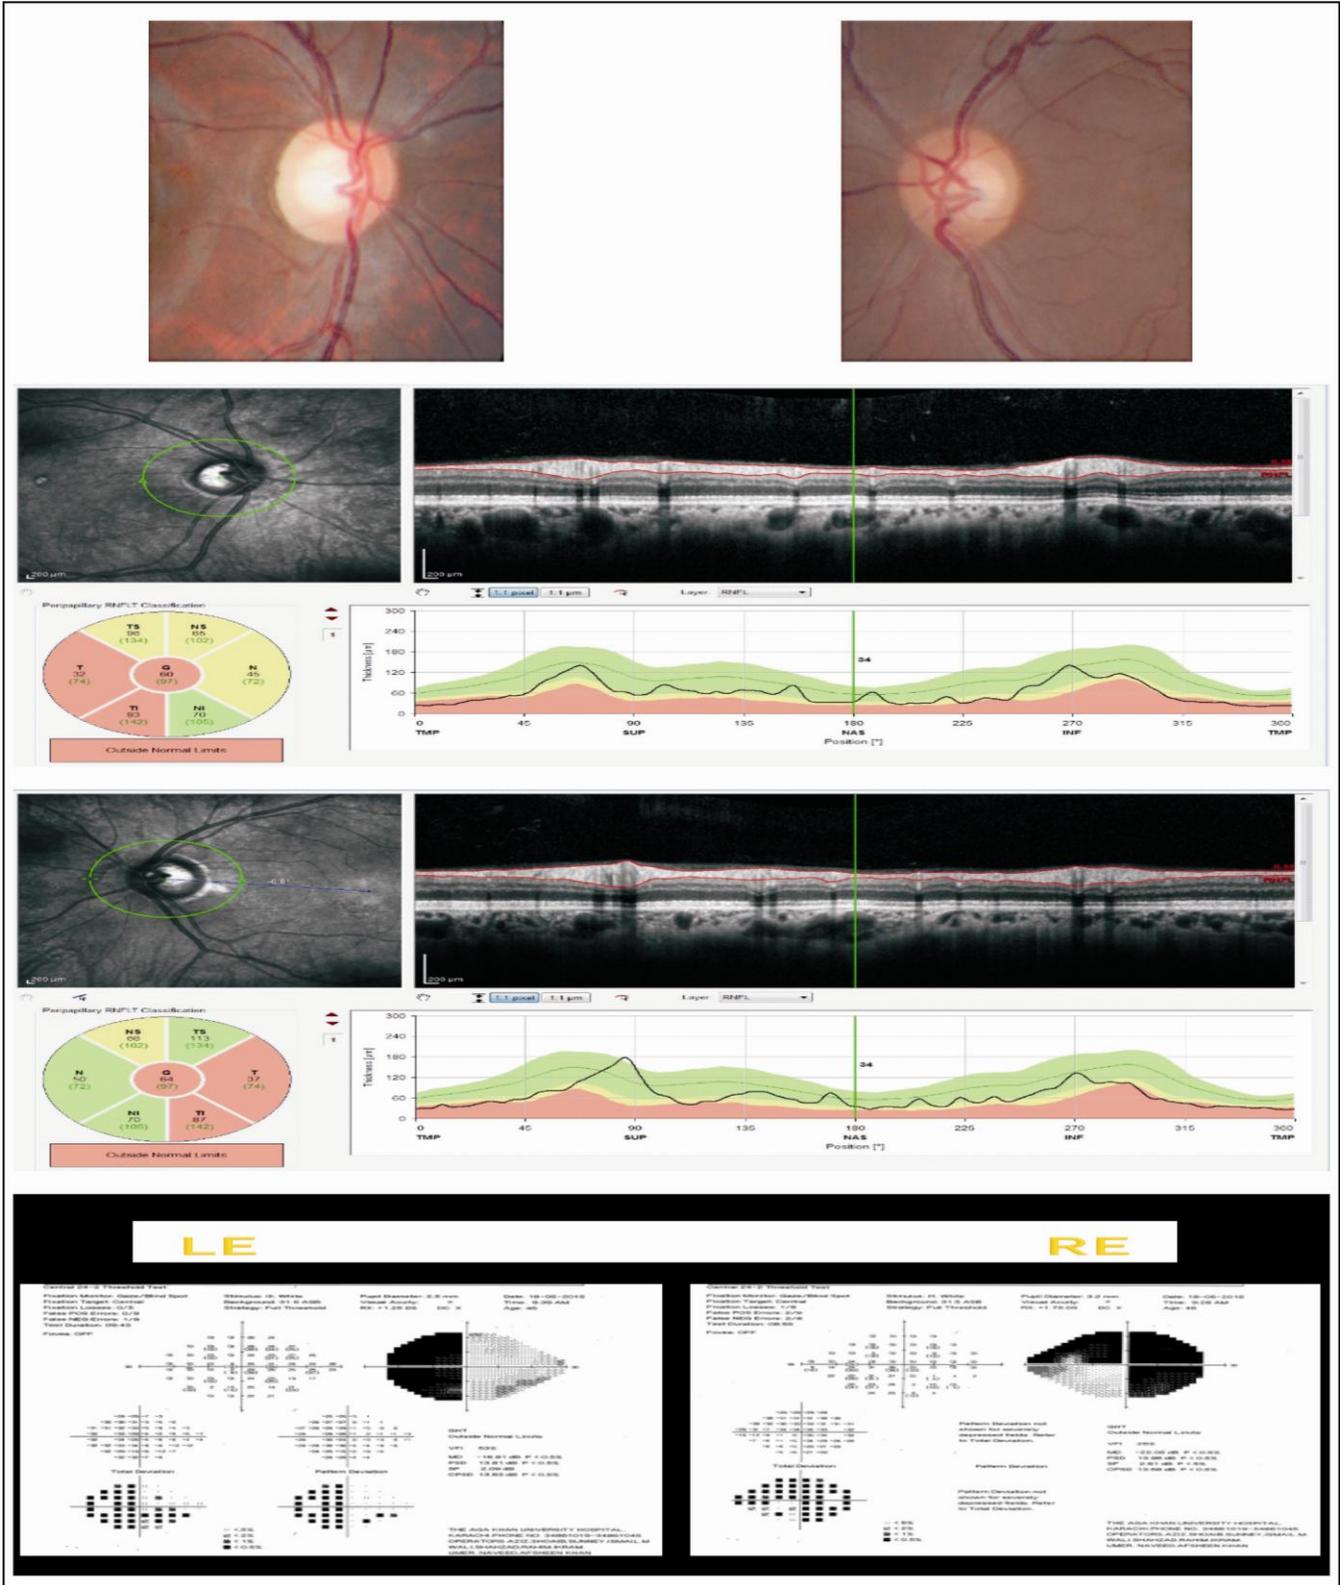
Patient with bitemporal hemianopia with corresponding changes on RNFL analysis. MRI confirmed presence of pituitary macroadenoma
